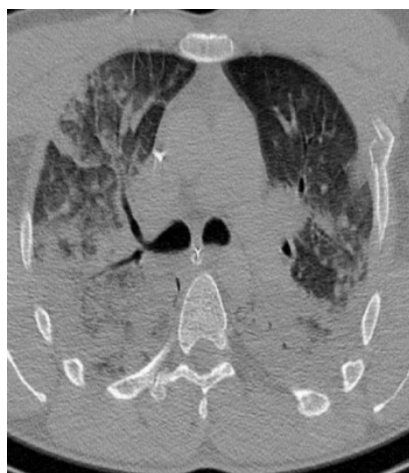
Chest CT 1 hour after admission
